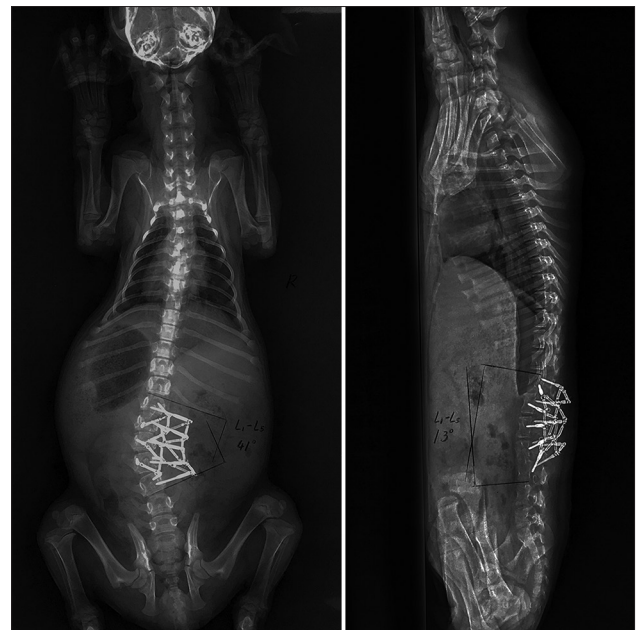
Posteroanterior and lateral radiographs of the spine two weeks after surgery.
